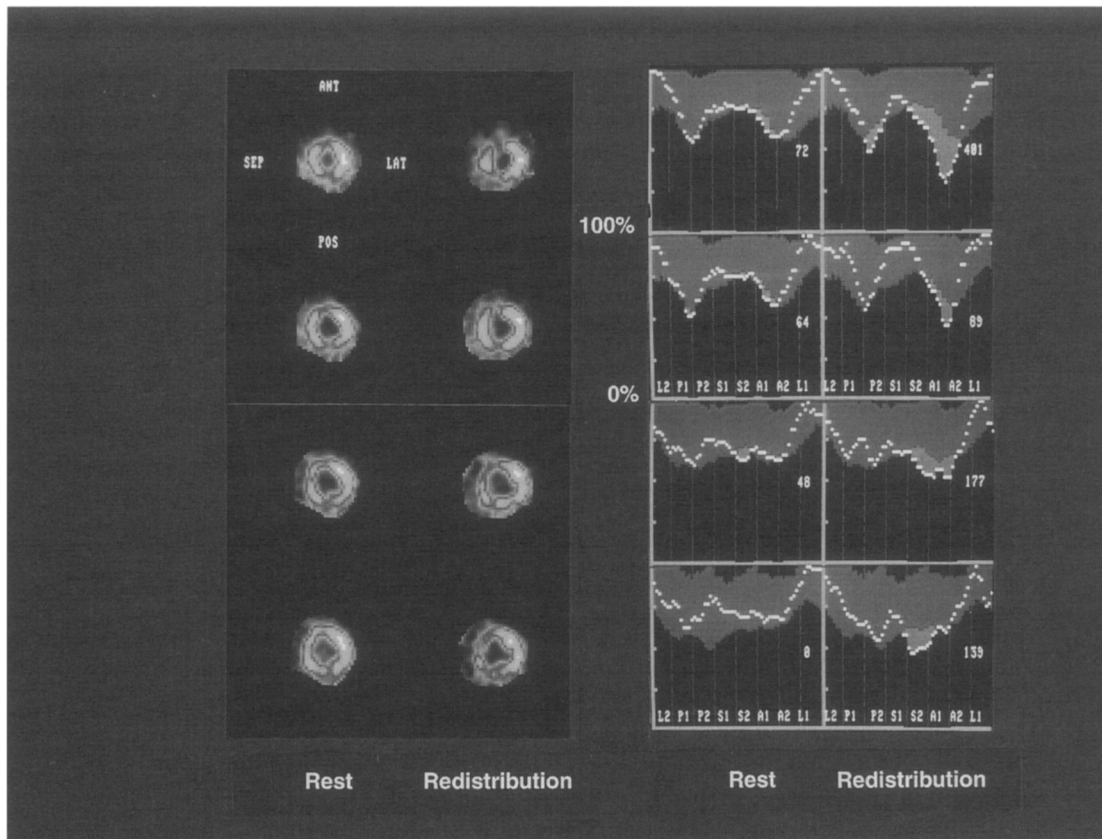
Same patient as in Figs. 5 and 6. RR Tl SPECT images in short-axis slices from apex to mid septum (top to bottom) with corresponding circumferential profile analysis shows viability of septum evidenced by normal rest perfusion.
